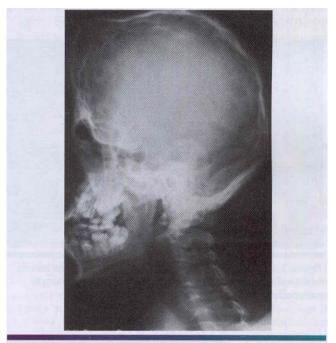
• Apert syndrome. Radiograph showing "tower skull," midface hypoplasia, and digital markings. Similar digital impressions are apparent in people with Crouzon syndrome. (Courtesy of Dr. Robert Gorlin.)
